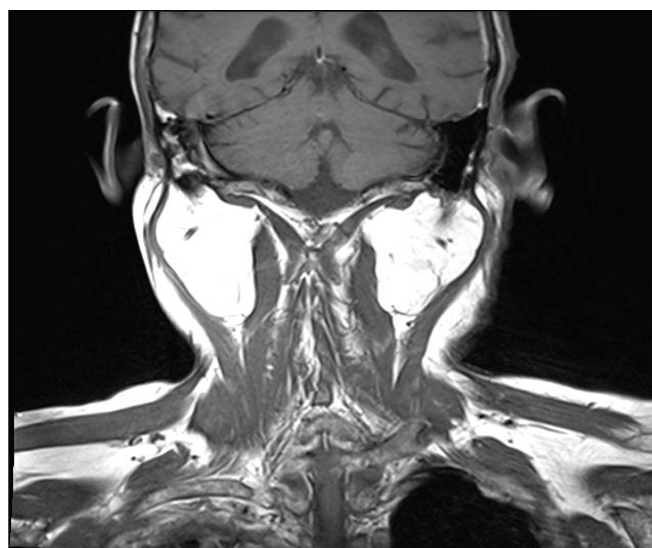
Magnetic resonance imaging revealed bilateral symmetrical lipomas.
